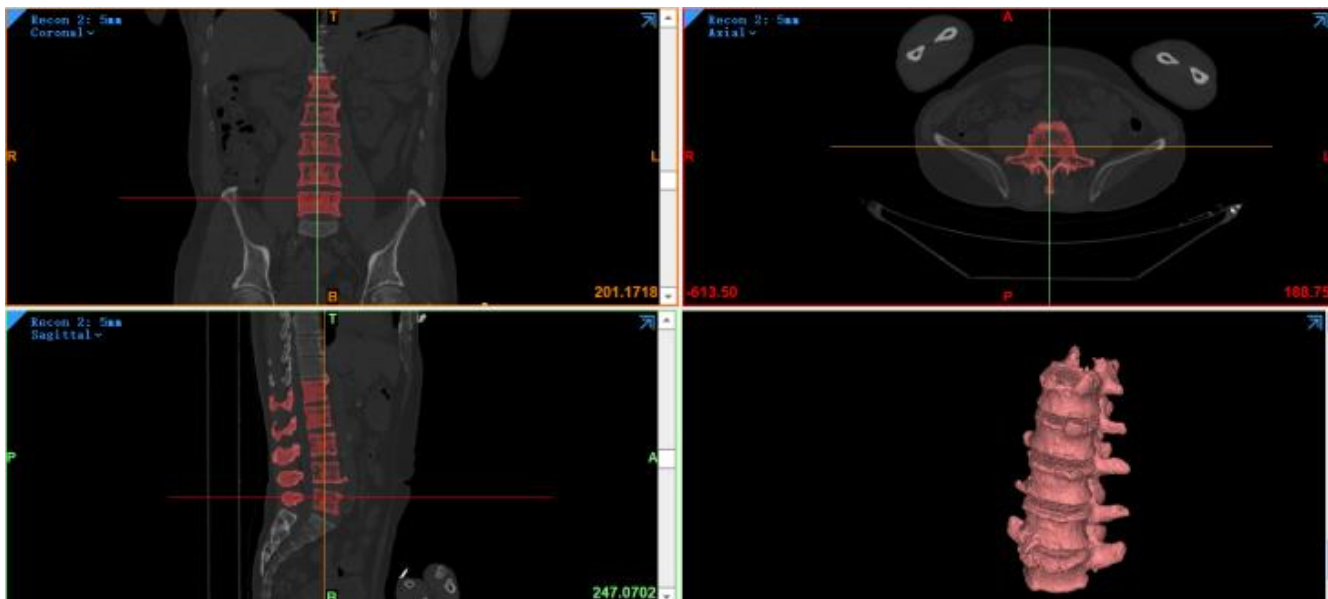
Lumbar spine CT image
